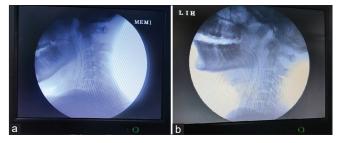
Initial intraoperative X-ray (a) with full-neck flexion showing endotracheal tube kink at the posterior aspect of the tongue and subsequent X-ray showing (b) opening up of the lumen partially with the extension of the head.
